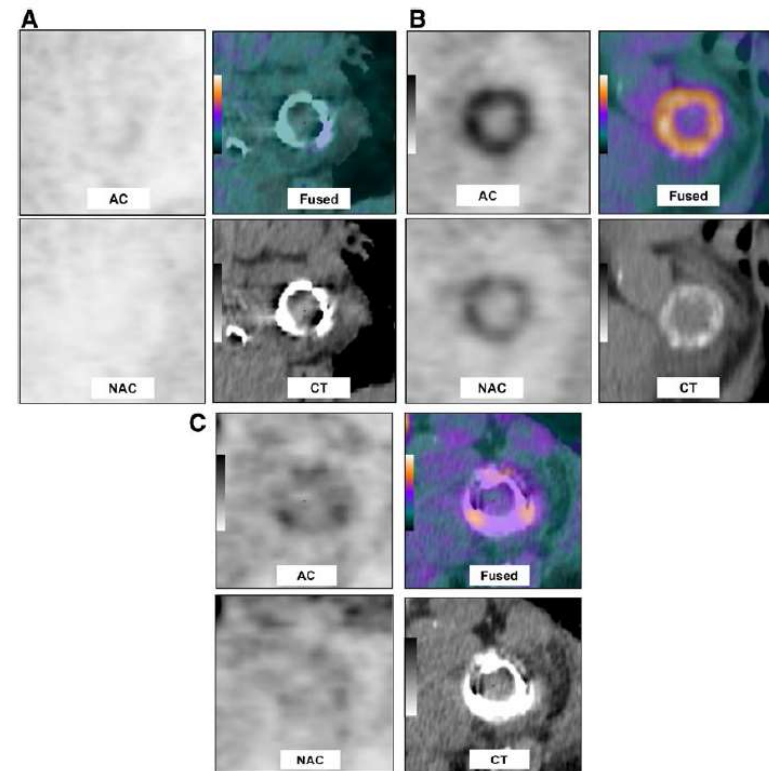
Examples of ^{18}F -FDG perivalvular uptake in noninfected patients.
